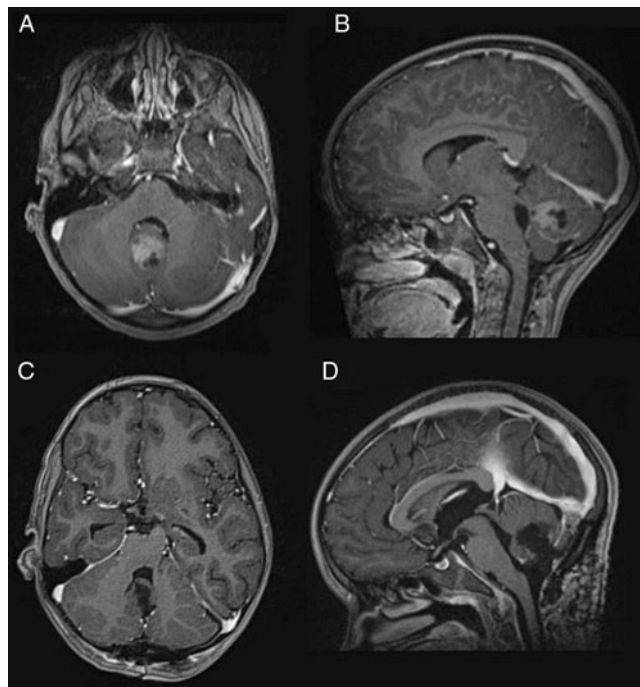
Pre- and postoperative MR images of a solitary cerebellar vermian lesion resected via posterior fossa craniotomy. A) Axial and B) sagittal contrast-enhanced T1-weighted MR images demonstrating a lesion arising within the inferior/middle cerebellar vermis with moderate mass effect on the fourth ventricle. C) Axial and D) sagittal contrast-enhanced T1-weighted MR images revealing complete resection of the lesion.
